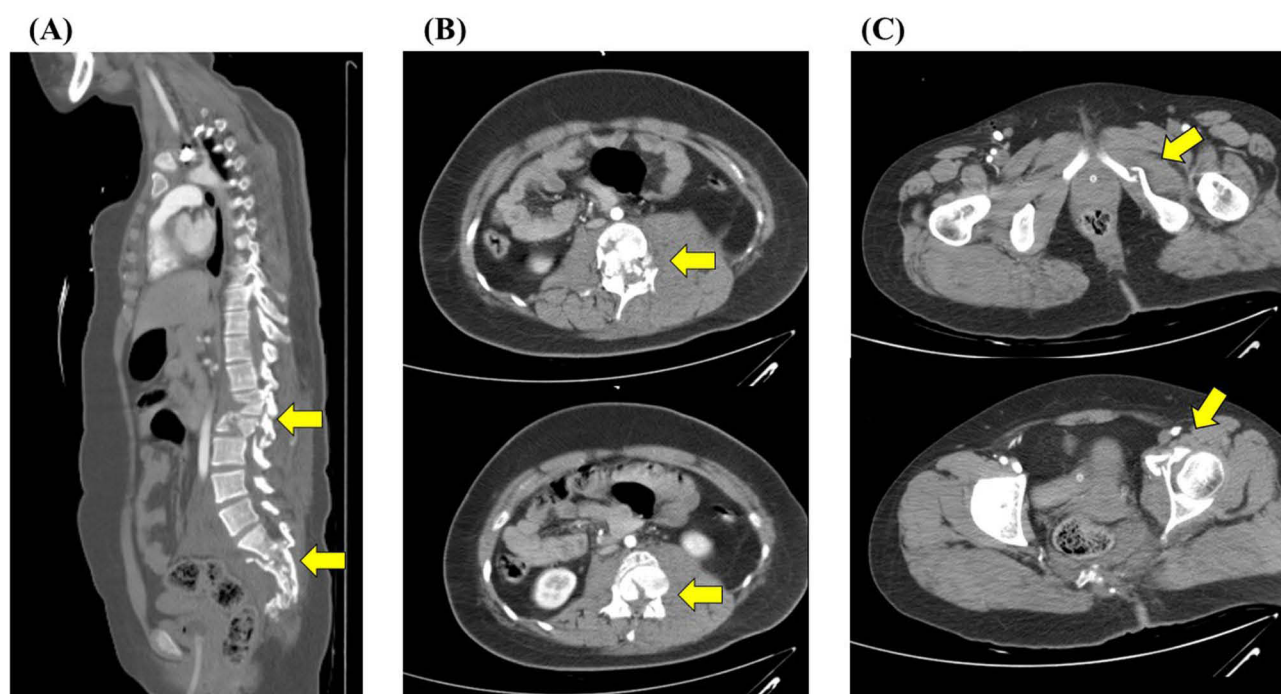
Computed tomography images taken immediately after the fall in January 20th, 2013 (Yellow arrows indicate fractures of spine). (A) Sagittal plane image showing multiple comminuted fracture at lumbar-sacral spine, coccyx, left anterior acetabulum and left inferior pubic ramus; (B) transverse plane image showing burst fractures with traumatic retrolisthesis in level L1-L2 and multi-level involvement of sacral neural foramen; (C) severe central canal and neural foraminal compromise at L1, L2 level.
